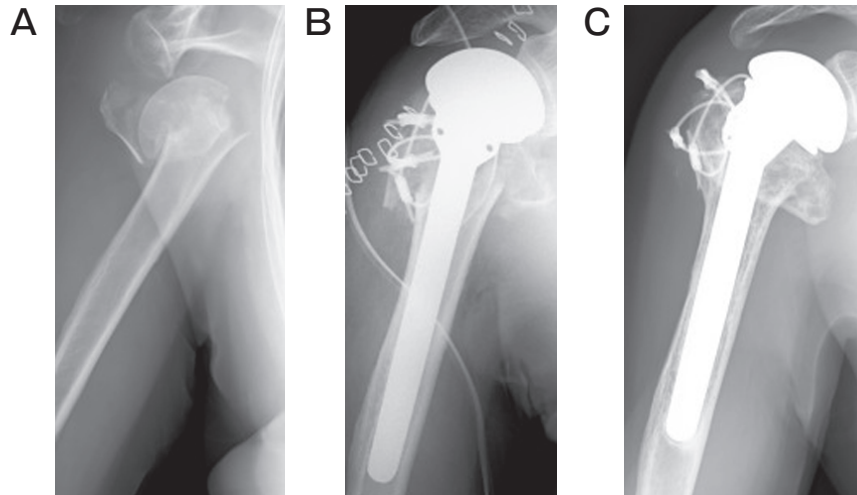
A, Anterior-posterior radiographs taken preoperatively; B, Immediately postoperatively; C, At 4 months postoperatively, showing bone union.
